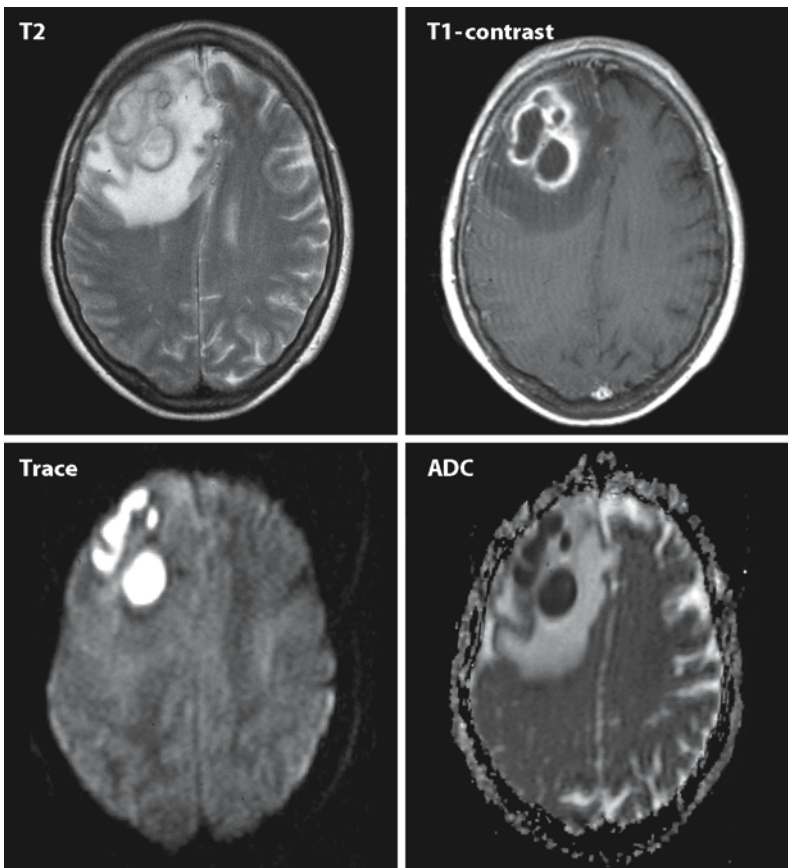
The practical use of DWI and ADC maps is also demonstrated in this 38-year-old female, in whom the conventional images suggested the diagnosis glioblastoma multiforme. The patient showed no sign of infectious disease either clinically or biochemically. The *upper two images*, T₂-weighted and T₁-weighted with contrast, show a multicystic lesion in the right frontal lobe, with edema and ring enhancement. The Trace images and ADC map on the lower row show that within the cysts water diffusion is severely restricted, indicating a possible abscess, which was confirmed at surgery
